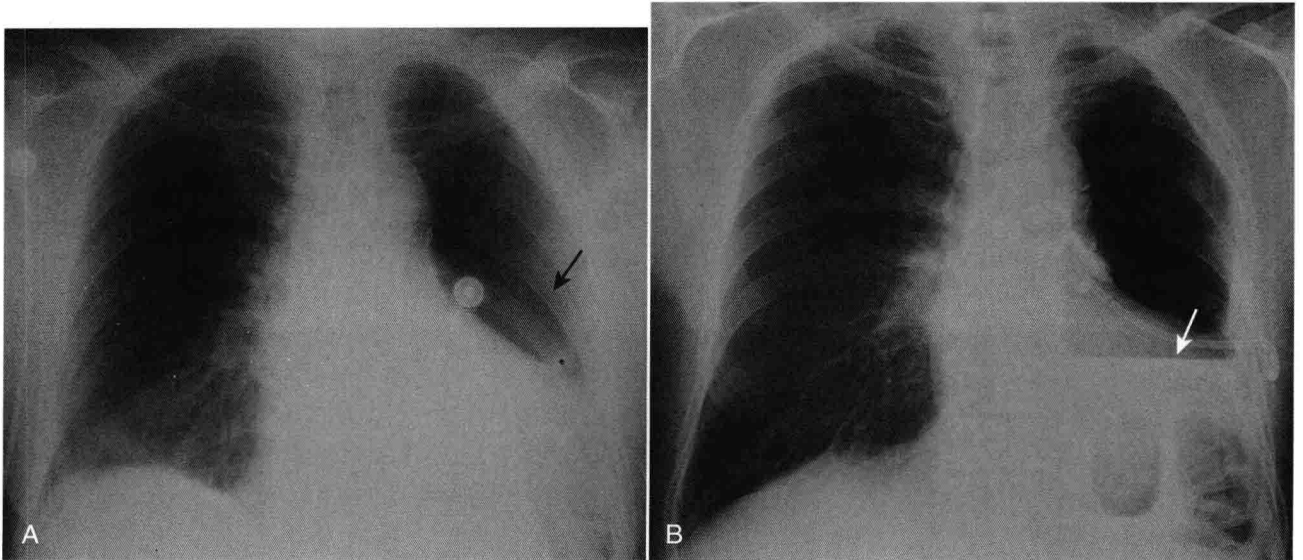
Vertical versus horizontal x-ray beam. The same patient with a hydropneumothorax is imaged a few hours apart, first with a vertical x-ray beam (A, supine chest) (solid black arrow) and then with a horizontal x-beam (B, upright chest) (solid white arrow). In both images, the patient has both air and fluid in the left hemithorax, but only in image B with the horizontal beam is the distinctive flat, air-fluid interface seen. An air-fluid interface will only be visible with an x-ray beam that is parallel to the floor (horizontal) no matter what position the patient is in.
